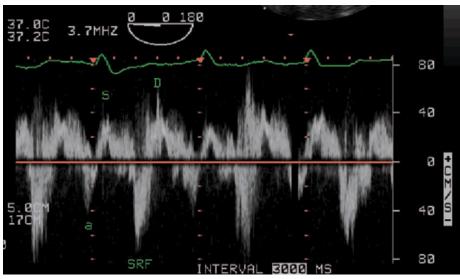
Characteristic pattern of a pulmonary venous Doppler signal, with a large systolic reverse flow wave (SRF) and an enlarged reverse atrial contraction wave (a).
